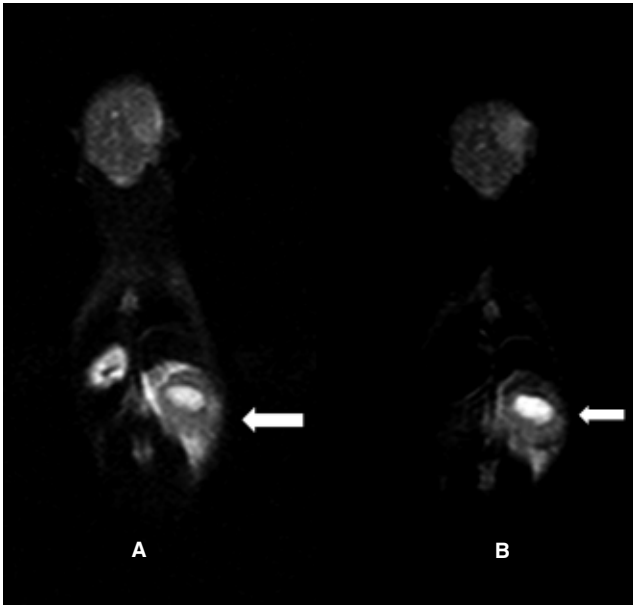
Indirect tumor targeting in D430B pseudo-metastases lymphoma. On T2-weighted images, before (A) and after (B) USPIO-anti-biotin administration. There was a decrease in signal intensity in D430B.
